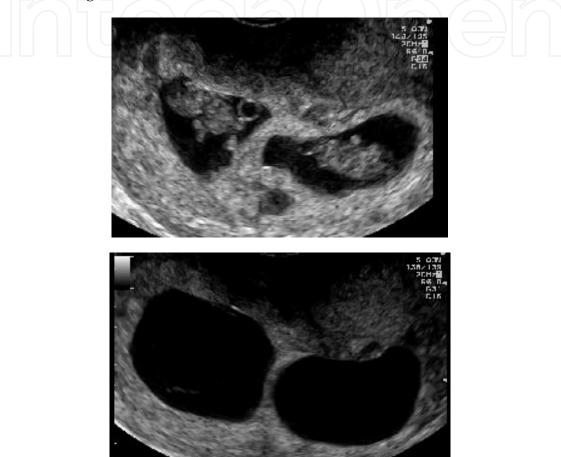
Chorionicity determination in the first trimester. Ultrasound images of dichorionic pregnancies. The 'full' lambda sign reflects the apposition of the two placental disks.
